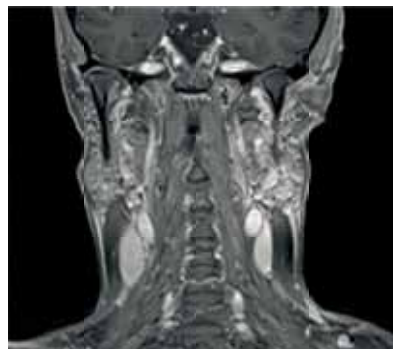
Coronal MRI scan of progressed stage of SS (Source – own clinical material).
